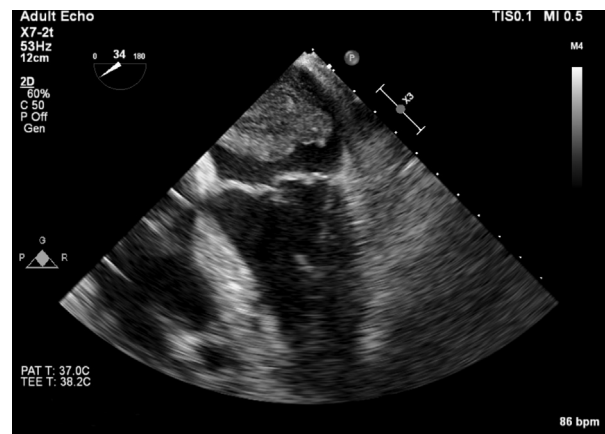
Midesophageal four-chamber transesophageal echocardiography view obtained during systole showing large left atrial mass occupying the majority of the left atrium.
